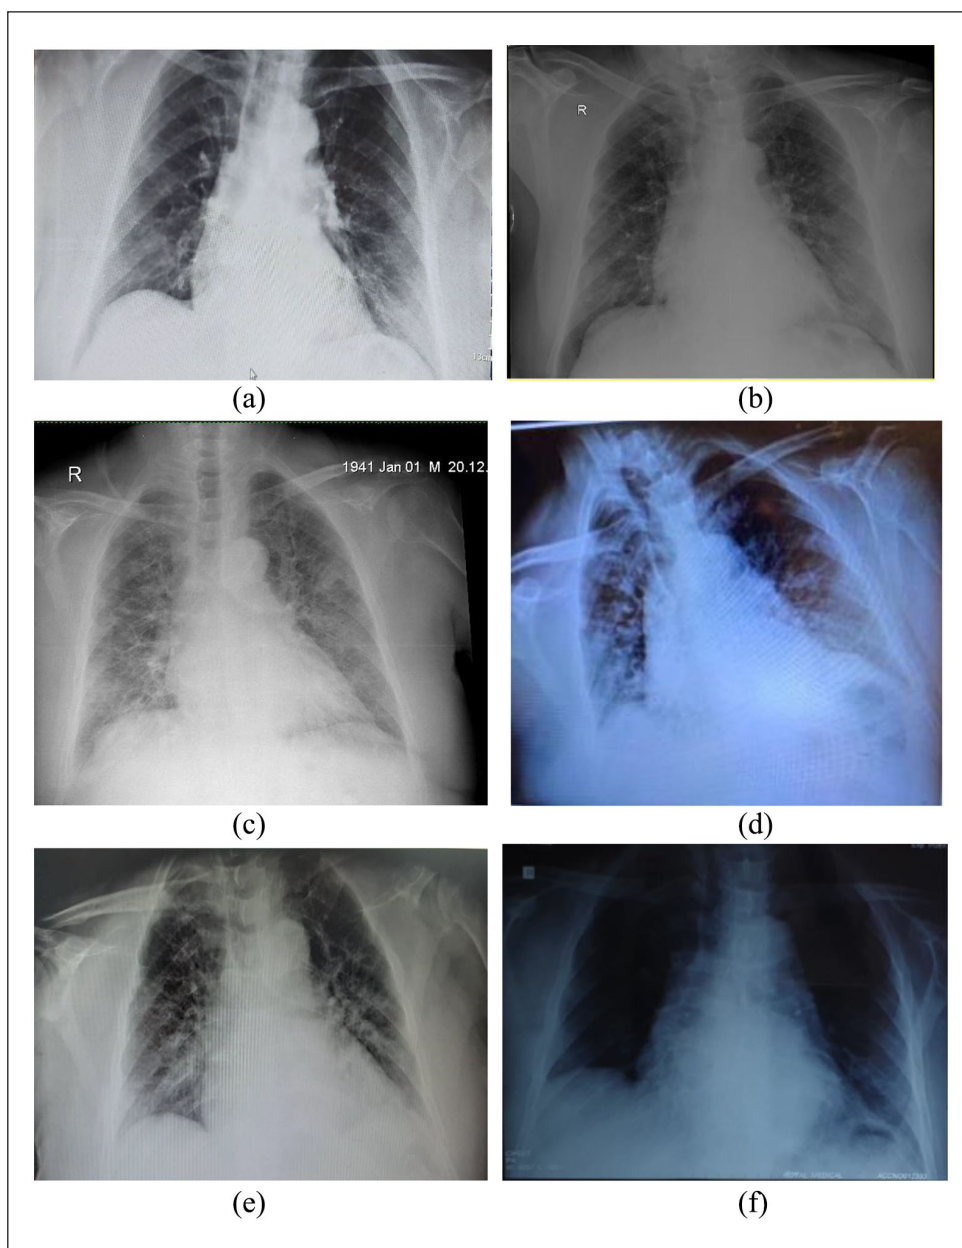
(a) Pulmonary X-ray image showing slight pulmonary infiltration. (b) X-ray image showing bilateral pulmonary infiltrates. (c) X-ray image showing diffuse bilateral atypical inflammatory infiltrates. (d) X-ray image showing inhomogeneous basal shading. (e) X-ray image showing improvement of inhomogeneous shading. (f) Pulmonary X-ray image revealing significant improvement in lung lesions.
